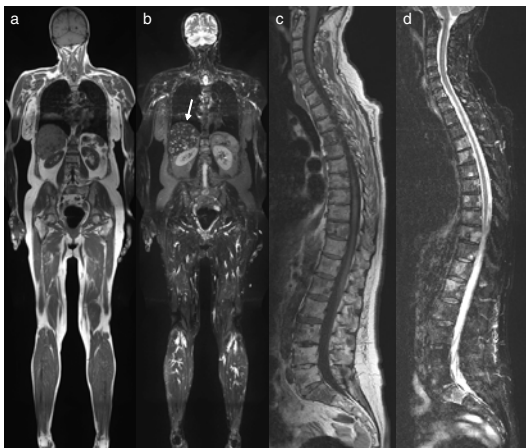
Whole-body MRI of a 62-year old patient with breast carcinoma using T1-w SE and STIR imaging on 5 body levels (a+b). Sagittal imaging of the spine reveals extensive mixed osteoblastic and osteolytic bone disease. The arrow in Figure 1b points out liver metastases as additional finding.
